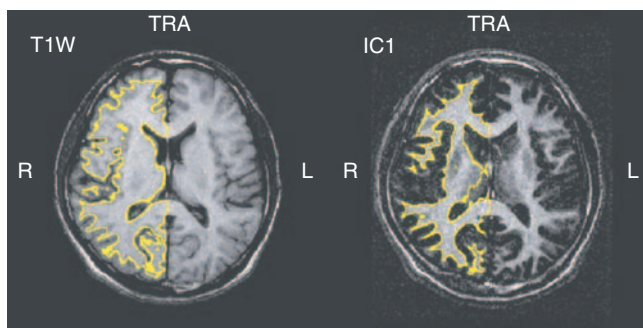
T1- and T2-weighted images. Note that the brain tumor can be hard to see on a T1-weighted image, while it is easy to see on the T2-weighted image – it is the round dark spot on the left of the brain image on the right. Source: Nakai *et al.*, 2004.
